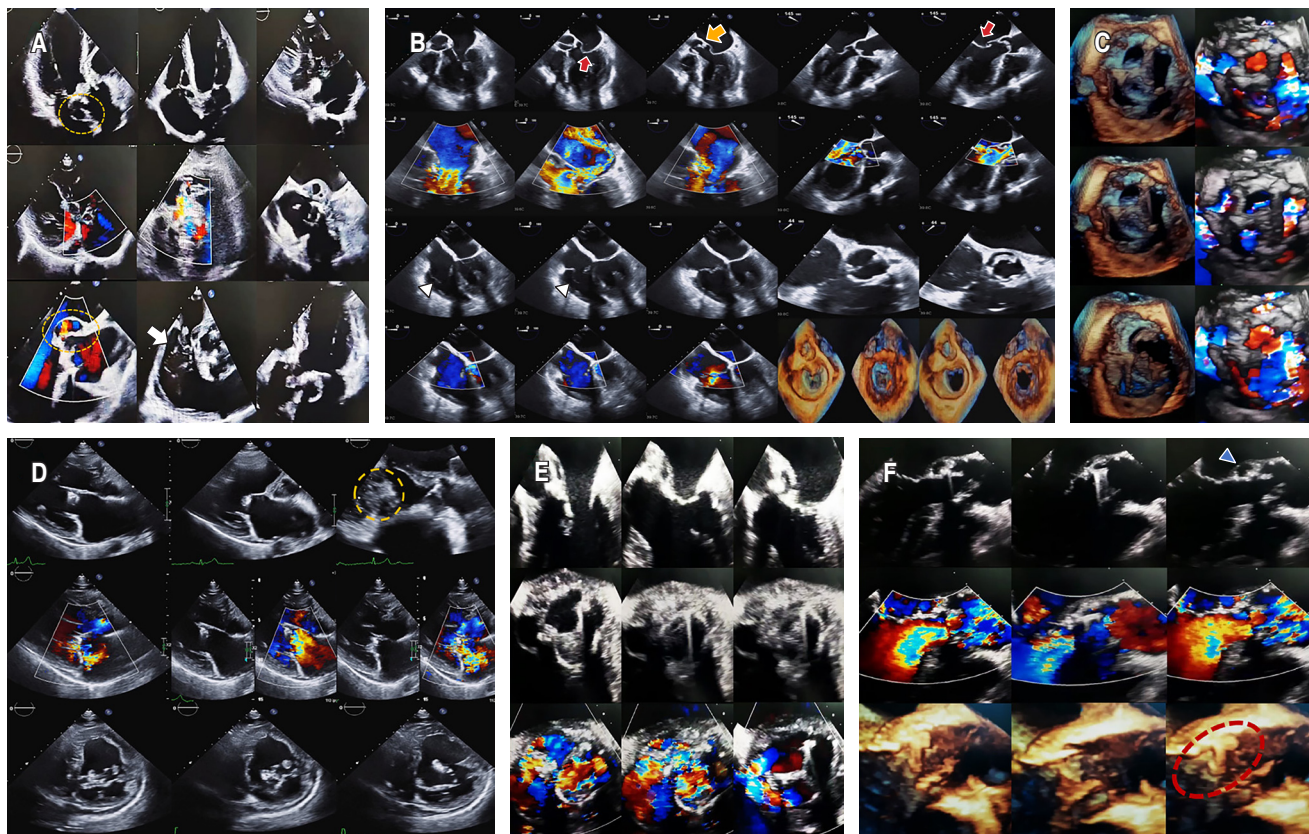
A) Apical and parasternal short-axis views of a case of bioprosthetic aortic valve endocarditis complicated by aortic root abscess (dotted circle), fistula draining into the right atrium, and native valve endocarditis of the tricuspid valve, which presents a large, non-mobile vegetation dependent on the septal leaflet (white arrow). B) TOE projections and 3D reconstruction. In the first row A3 at 0°, excursion of the thin mitral valve leaflets and prolapse of A2, as well as prolapse of the right coronary cuspid of the aortic valve (yellow arrow) can be seen. At second row colour Doppler shows 2 mitral regurgitation jets, the largest of which runs in a posterolateral direction towards the left atrial wall, reaching its roof, and the aortic valve regurgitation jet spanning the length of the LVOT. Below A4 at 0°, shows thin and elongated TV leaflets with anterior leaflet prolapse (white triangle). Right side A3 at 145° focused on the LVOT with colour and PSAX with zoom on the aortic bicuspid valve, which has sclerotic leaflets and an ovoid lesion suggestive of vegetation. 3D reconstruction of the atrial view and ventricle view where a perforation is observed in the anterior veil of the left ventricle. C) 3D reconstruction from the atrial view of a mitral bioprosthesis during the cardiac cycle. Color Doppler imaging reveals the presence of an anteroseptal paravalvular leak and mitral annulus dehiscence in the posterolateral region. D) A case of congenitally corrected transposition of the great arteries complicated by pulmonary valve endocarditis with ventricular septal defect. The patient was characterized by situs solitus with a morphologically right ventricle, Tricuspid atrioventricular Valve (TV) with severe regurgitation, and muscular Ventricular Septal Defect (VSD) with adherent vegetation extending toward the tricuspid septal leaflet. Also, discordant ventriculoarterial connection with multiple vegetations in the pulmonary artery trunk and bifurcation, leading to severe supra-valvular pulmonary stenosis. E) Mitral and aortic endocarditis, with multiple vegetations causing severe regurgitation in both cases. A close-up of the A3 and bicommissural projection of a transesophageal echocardiogram in two-dimensional and color Doppler mode is shown. F) Native aortic valve endocarditis complicated by aortic root abscess (blue triangle). Multiple jets associated with valve perforation and the presence of several vegetations are seen (dotted oval).
